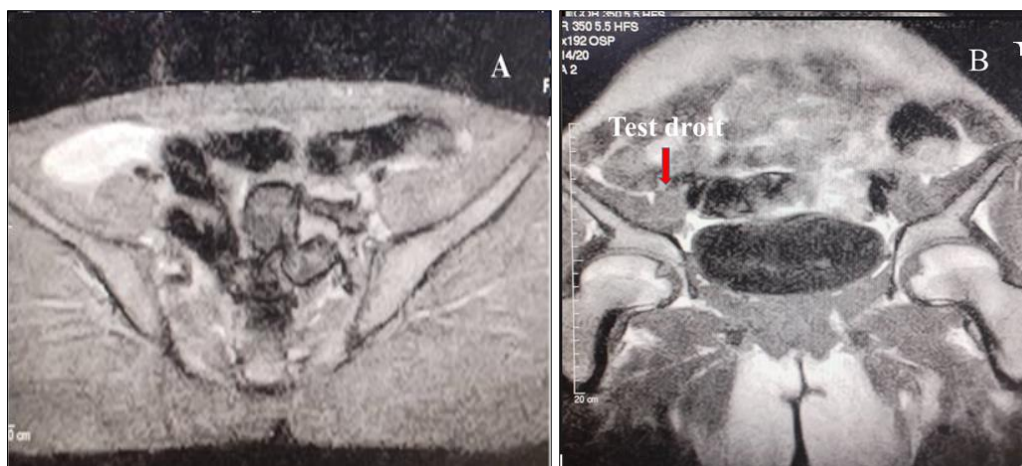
(A and B): MRI in axial T1 and coronal T1 sequence; showing the absence of the uterus or ovaries in a 22-year-old girl with the presence of a right testicle
